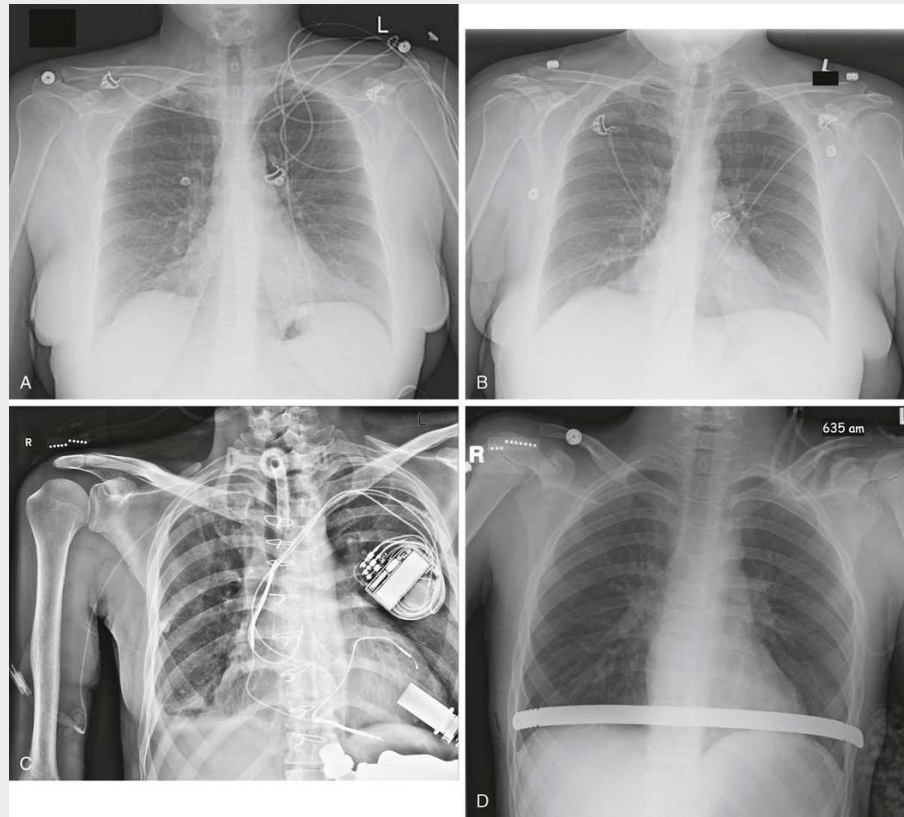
Mobile AP chest radiographs. (A) AP chest image with incorrect cephalic tube angle resulting in an apical lordotic image in which the ribs appear boxy, the clavicles are projected too high, and the heart has a distorted silhouette. A tangle of lead wire is seen over the upper left chest. (B) Repeat image with the correct angle, central ray perpendicular to the long axis of the sternum. The radiographer has also positioned the lead wires appropriately. (C) Mobile peripherally inserted central catheter (PICC) placement image to visualize the PICC line from entrance to tip. Also seen are the tracheostomy, pacemaker, sternal wires, and ventricular assist device. (D) Adolescent postoperative patient with strut placed for pectus excavatum repair. Ice pack is seen in the lower right corner of the image.
